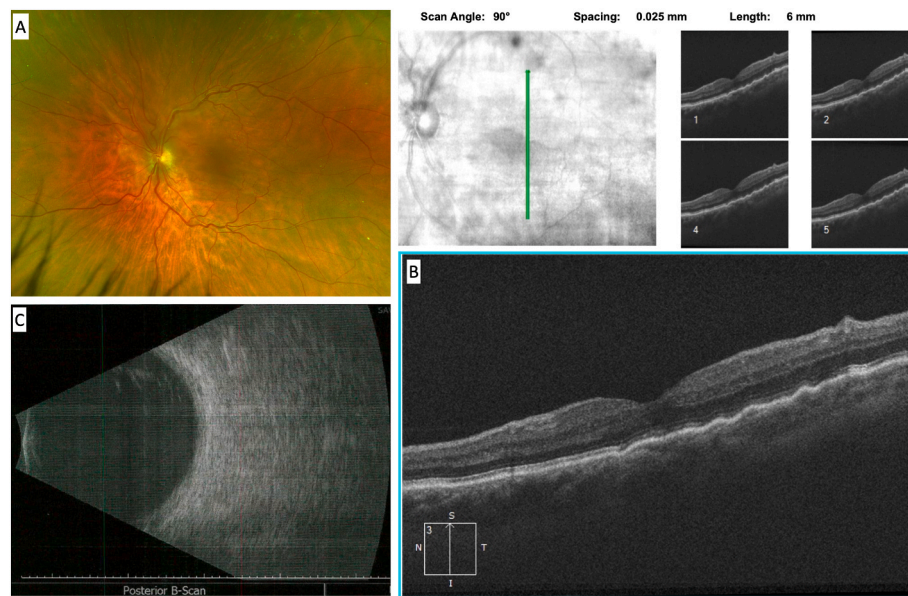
Left eye imaging at 4 weeks after diagnostic: (A) color fundus photography showing a reduction of choroidal folds (horizontal folds still visible at the macula); (B) macular optical coherence tomography showing an improvement of choroidal folds; (C) B-scan ultrasound showing a reduction in scleral thickness. (For interpretation of the references to color in this figure legend, the reader is referred to the Web version of this article.)
